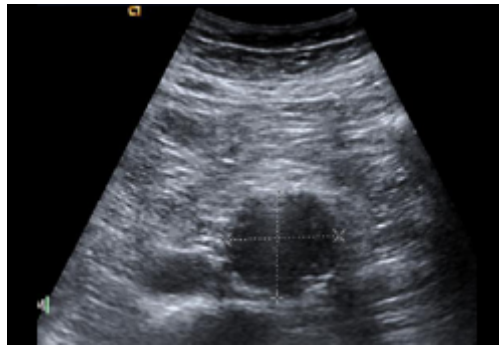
Ultrasound of a 3.8 cm x 4.2 cm AAA
